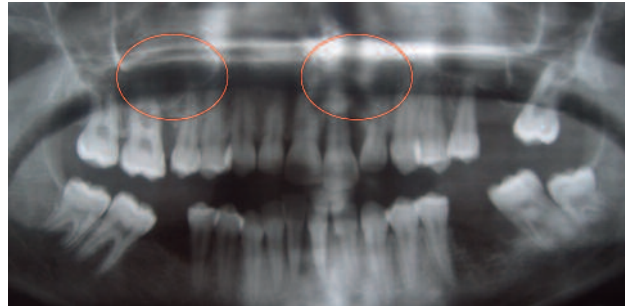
X-ray :Generalised lysis at the level of the maxillary
